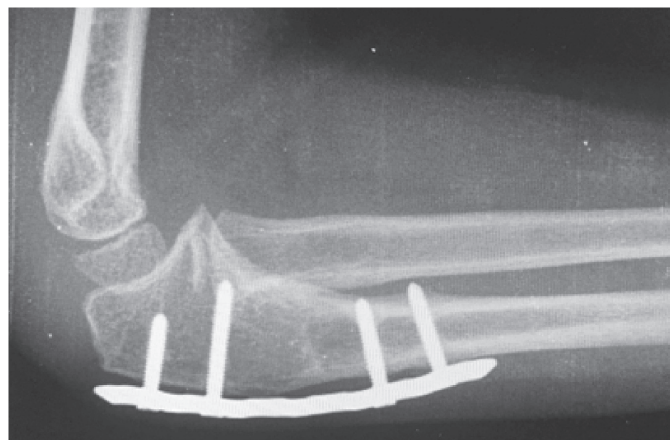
Post-operative 6 month lateral radiography after correction of chronic Monteggia fracture-dislocation.
